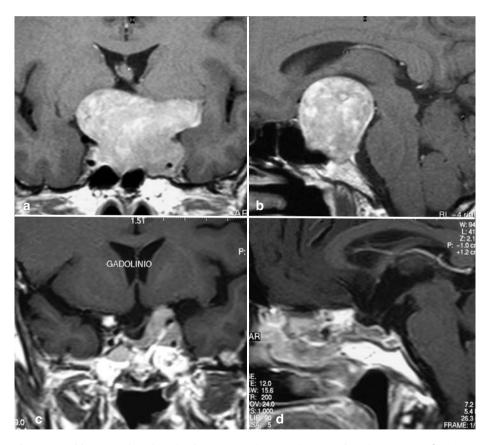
a, b) Coronal and sagittal pre-operative MRI images showing a case of a giant adenoma. c, d) Coronal and sagittal post-operative MRI images of the same patient showing the subtotal removal of the lesion
